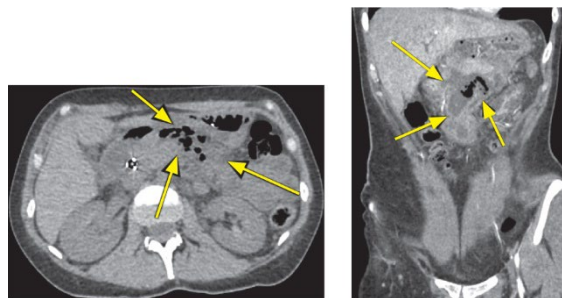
Computed tomography of the abdominal cavity with intravenous contrast. Arrows indicate the boundaries of the fluid accumulation with gas inclusions. Biliary duodenal stent
